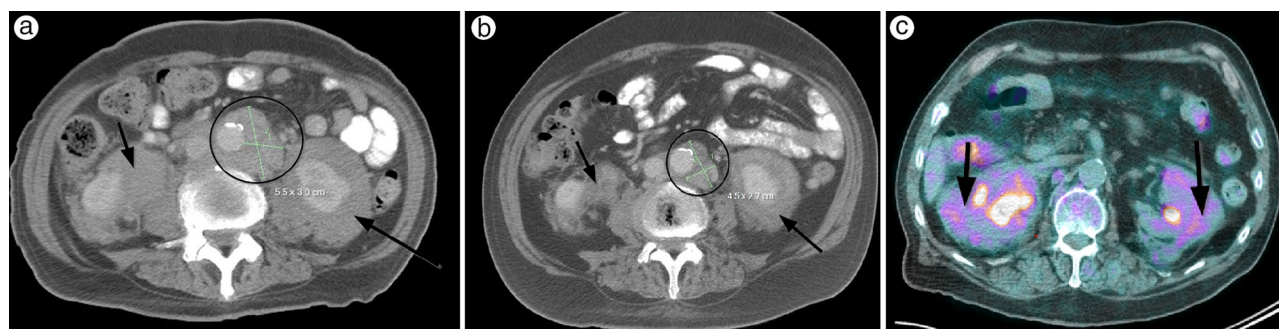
CT of the abdomen and pelvis with intravenous and oral contrast (a) prior to treatment and (b) following treatment showing decreased size of the paraaortic lymphadenopathy (circle) and perinephric soft tissue rind (arrows). (c) PET/CT fusion image. The F-18 FDG accumulation shown in the perinephric soft tissue rind bilaterally is compatible with disease involvement (arrows).
